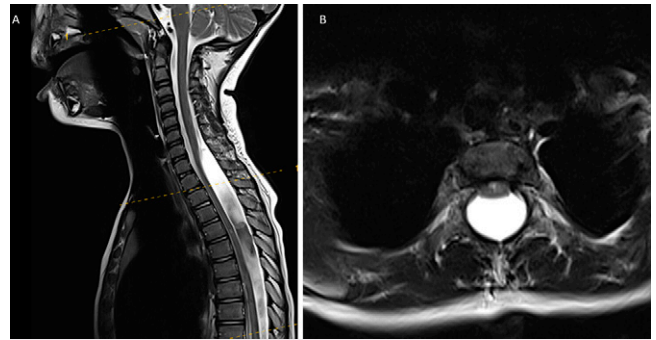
Preoperative MRI of the spine, demonstrating dorsal thoracic arachnoid cyst with spinal cord compression. A: Sagittal T2-weighted image. B: Axial T2-weighted image.
